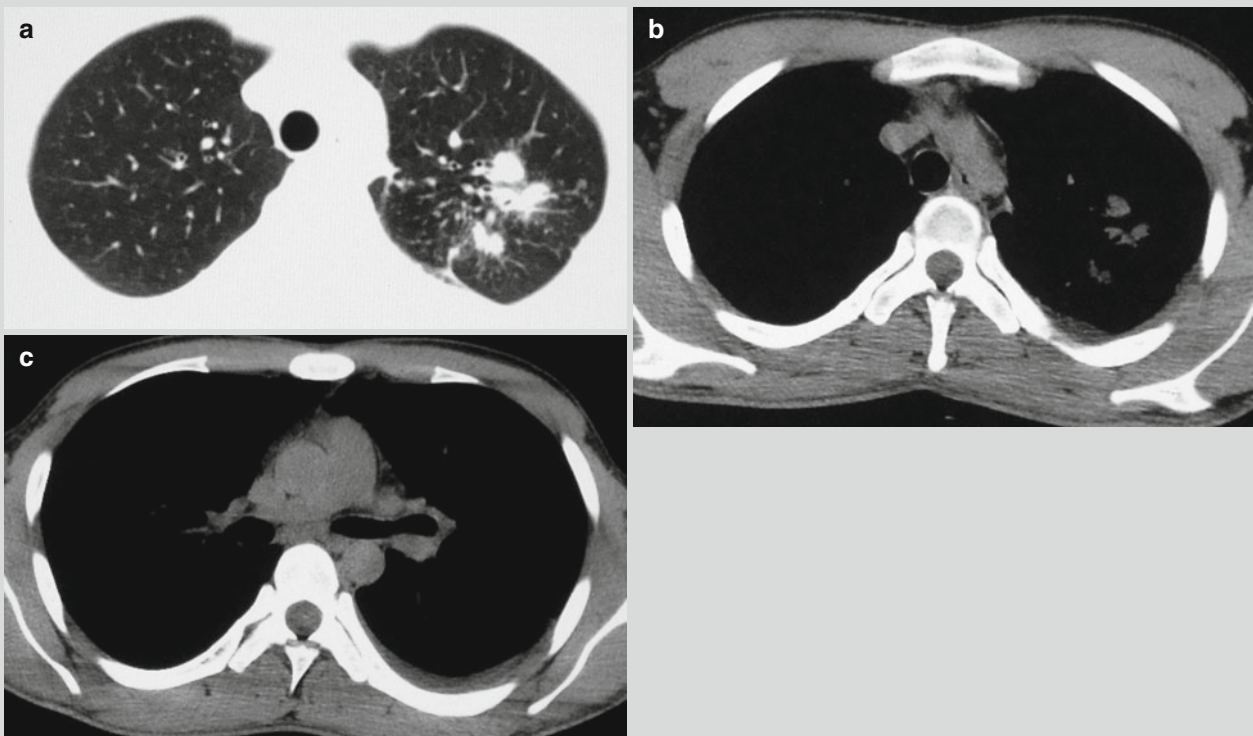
Tuberculous exudative pleuritis (free pleural effusion). (a–c) CT scanning demonstrates spots and patches of shadows at the apical posterior segment of the left upper lung lobe and crescent-shaped liquid density shadow at the left thoracic cavity
